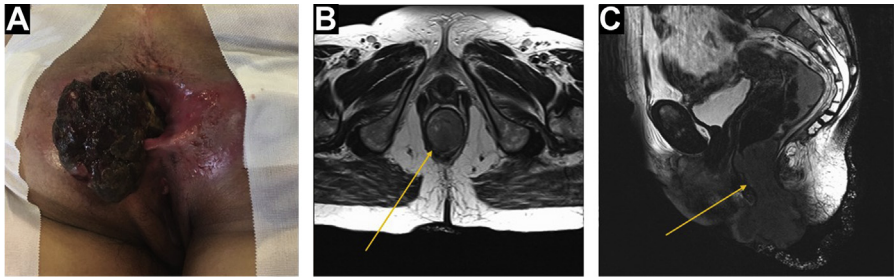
Rectal melanoma with a long stalk and bulky disease extending past the anal canal on physical examination (A) and pelvic MRI (B, C; arrows).
